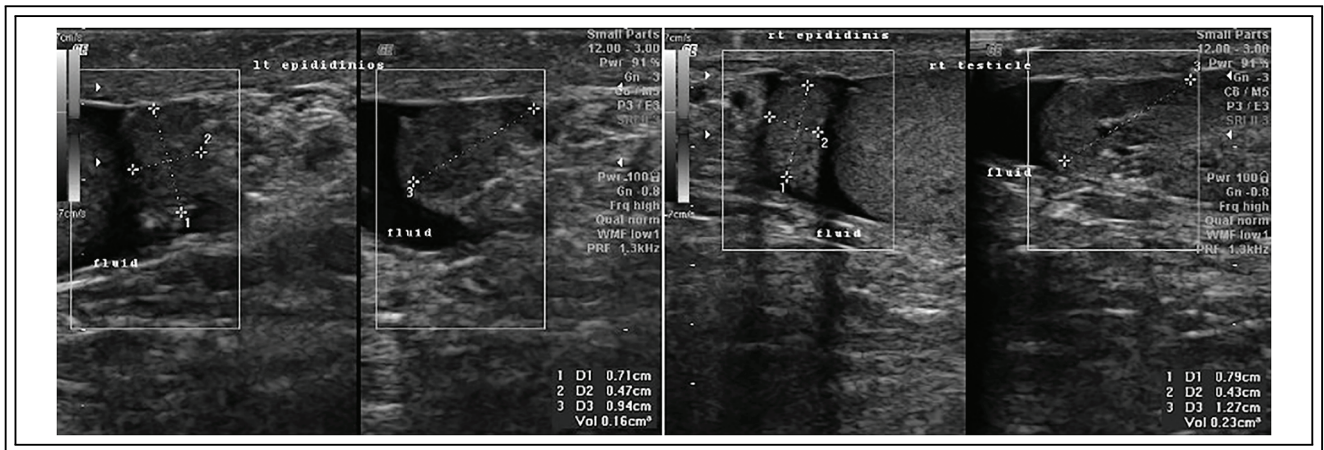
Doppler ultrasonography of the left and right epididymis
